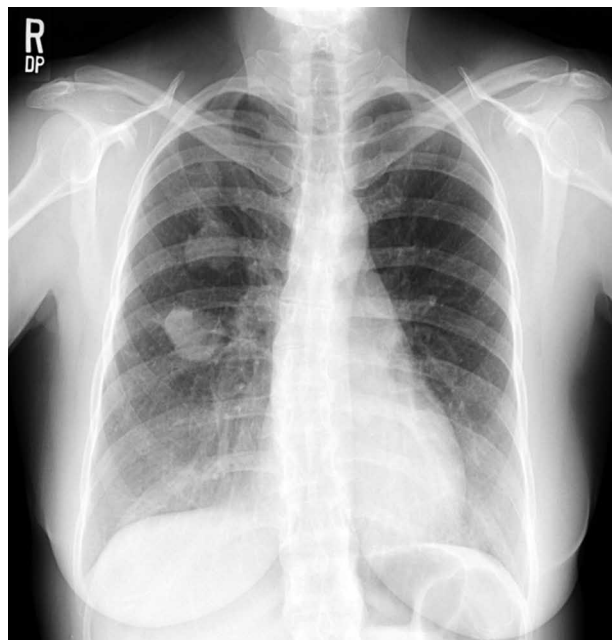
Chest radiograph showing two circumscribed masses in the right upper lobe, close to the right hilum.
